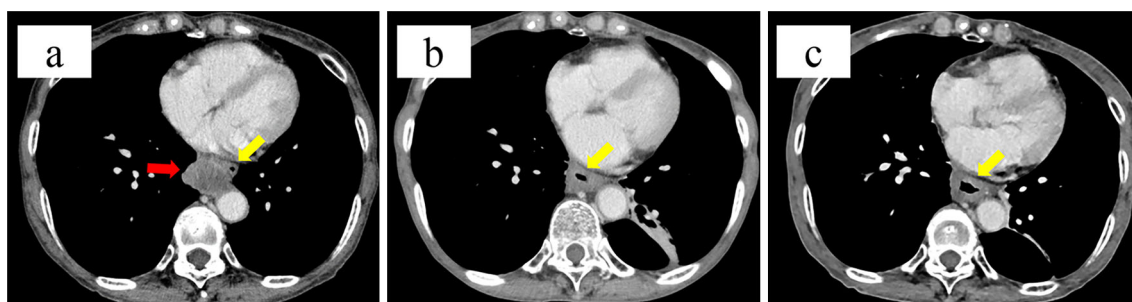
A computed tomography scan of the tumor images before (a), just after (b), and 18 months after (c) the chemoradiation therapy. The tumor (red arrows) near the esophagus (yellow arrows) has remarkably decreased in size and it has almost completely disappeared.
